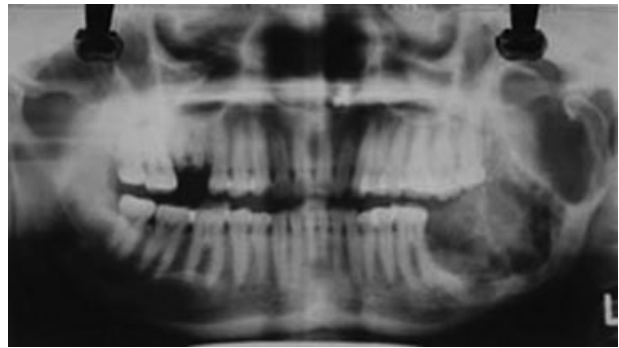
Preoperative orthopantomogram of a patient showing the extent of the lesion, 105 × 59 mm (72 × 72 DPI).
